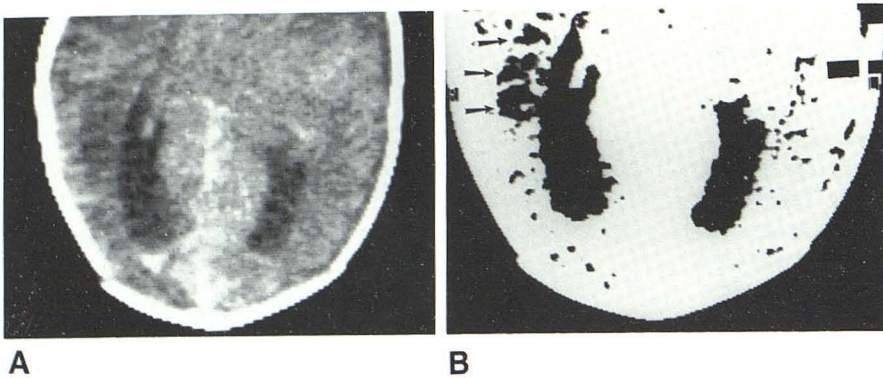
3-week-old premature neonate. A, Periventricular hypodensity on CT. B, Manipulation of window level and window width identifies multiple small cysts (*arrows*) along lateral border of right lateral ventricle.
